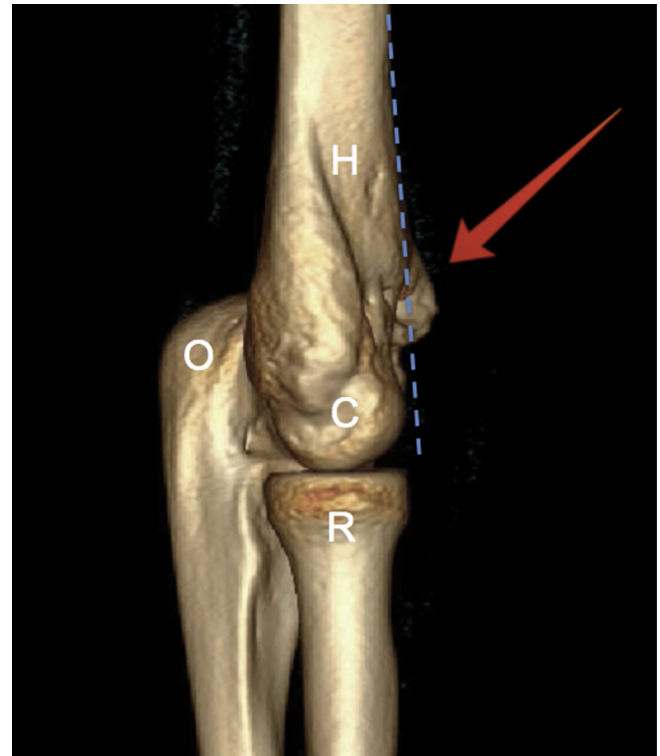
Computed tomography scan with 3-dimensional reconstruction of a right elbow showing extension malunion of the distal humerus with heterotopic bone in the coronoid fossa (red arrow), which is likely limiting elbow flexion. The dashed blue line represents the anterior humeral line. (H, humerus; O, olecranon; C, capitellum; R, radius).
